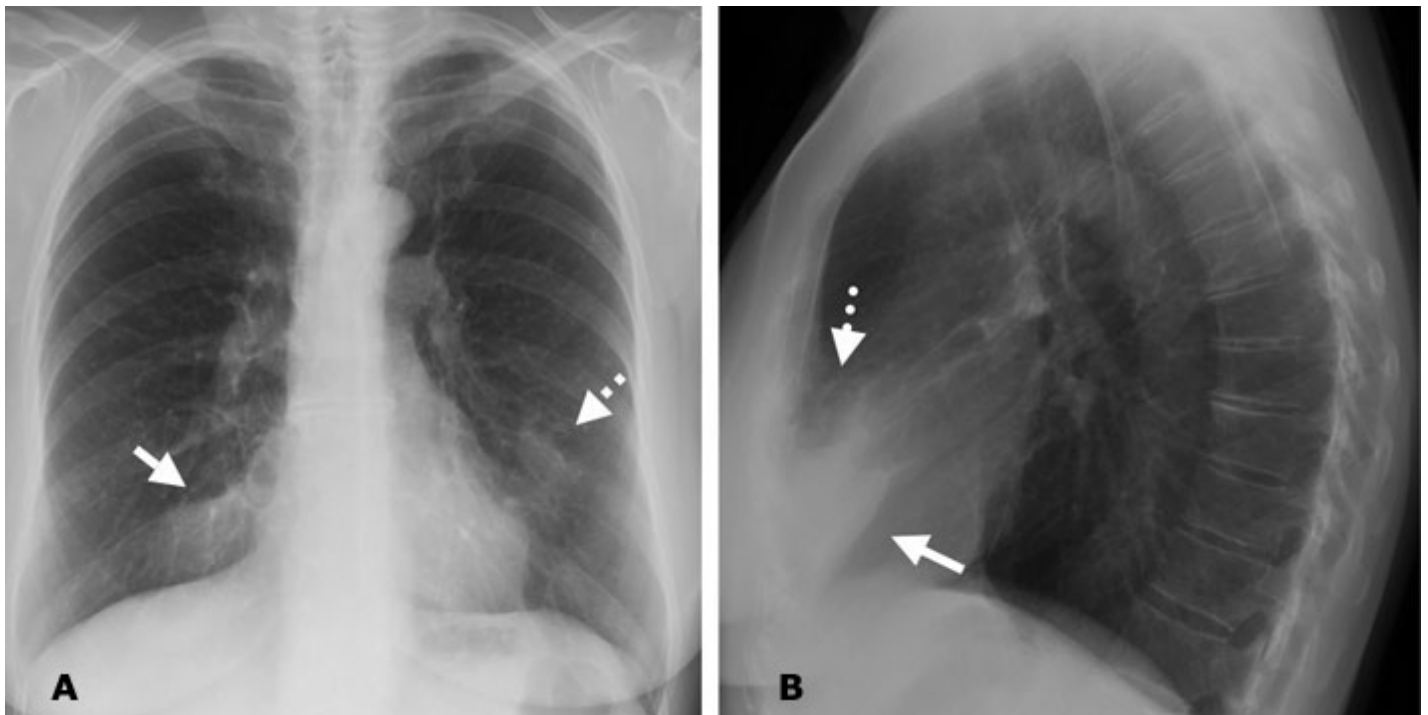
PA (1A) and Lateral chest (1B) radiographs in a 64 year old lady with a chronic cough secondary to MAC. There is air space opacity in the middle lobe (solid arrows) and lingula (dashed arrows)
